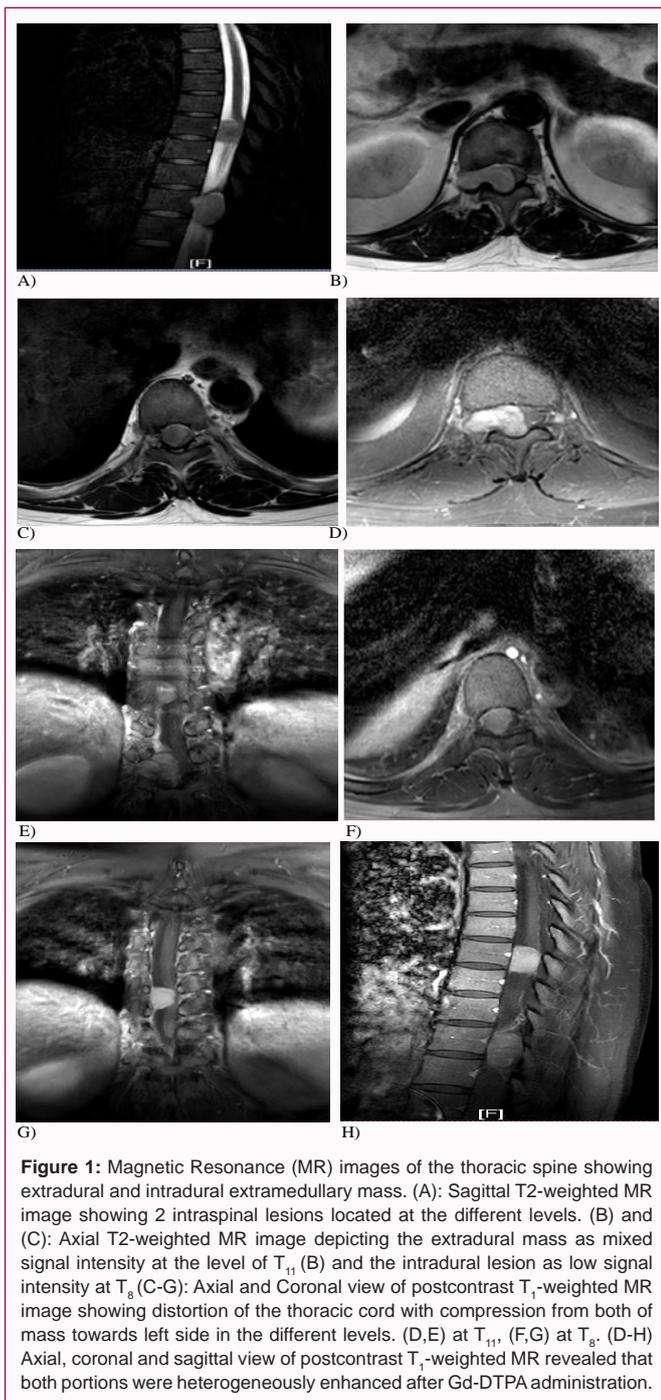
Magnetic Resonance (MR) images of the thoracic spine showing extradural and intradural extramedullary mass. (A): Sagittal T2-weighted MR image showing 2 intraspinal lesions located at the different levels. (B) and (C): Axial T2-weighted MR image depicting the extradural mass as mixed signal intensity at the level of T₁₁ (B) and the intradural lesion as low signal intensity at T₈ (C-G): Axial and Coronal view of postcontrast T₁-weighted MR image showing distortion of the thoracic cord with compression from both of mass towards left side in the different levels. (D, E) at T₁₁, (F, G) at T₈. (D-H) Axial, coronal and sagittal view of postcontrast T₁-weighted MR revealed that both portions were heterogeneously enhanced after Gd-DTPA administration.
